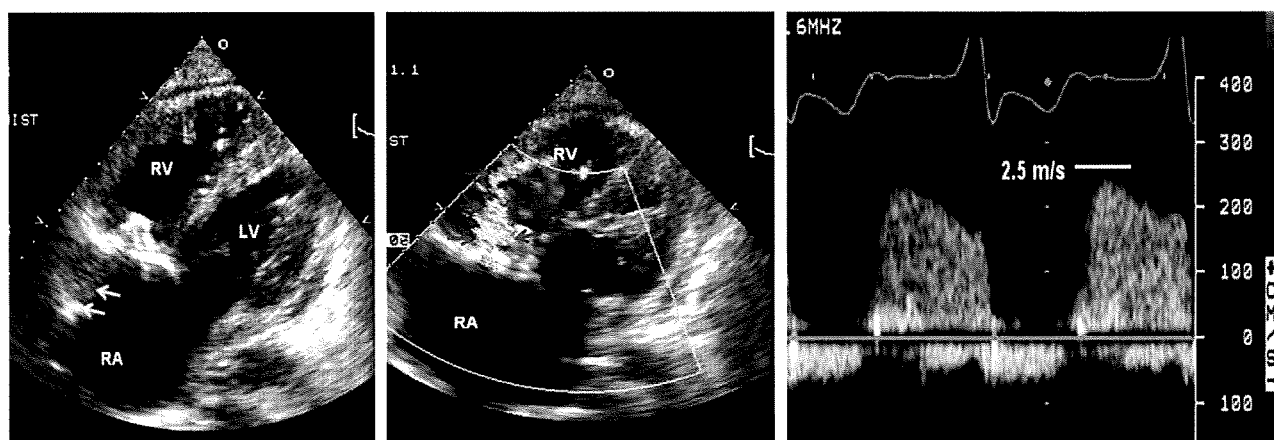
Transthoracic echocardiographic and Doppler images in a patient with normal prosthetic tricuspid valve and another with prosthetic stenosis. The case with normal prosthetic valve function had mild TR and a large central inflow jet in diastole. The patient with tricuspid valve stenosis had an eccentric narrow jet with an elevated velocity and mean gradient.
